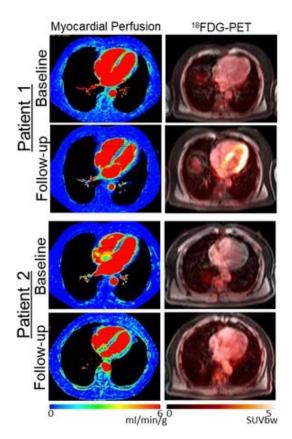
Baseline and 6-week follow-up of rest computed tomography (CT) myocardial perfusion images and [¹⁸F]fluorodeoxyglucose (¹⁸FDG)/positron emission tomography (PET) images of the heart. Note global increase of myocardial uptake can be seen in post radiation therapy (RT) PET imaging of both patients.
